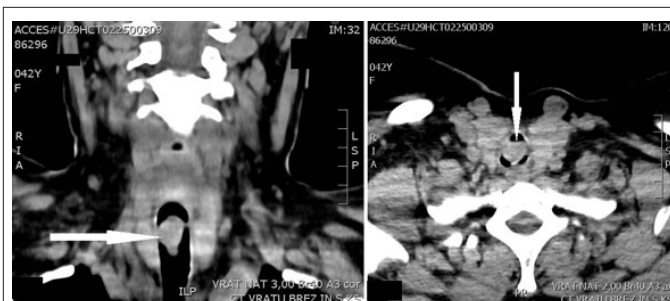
Contrast-enhanced computed tomography of the neck in the coronal plane (left) and axial plane (right), demonstrating an irregular soft-tissue mass in the upper trachea below the vocal cords. The lesion caused critical narrowing of the tracheal lumen to approximately 4 mm at its narrowest point (arrows).
